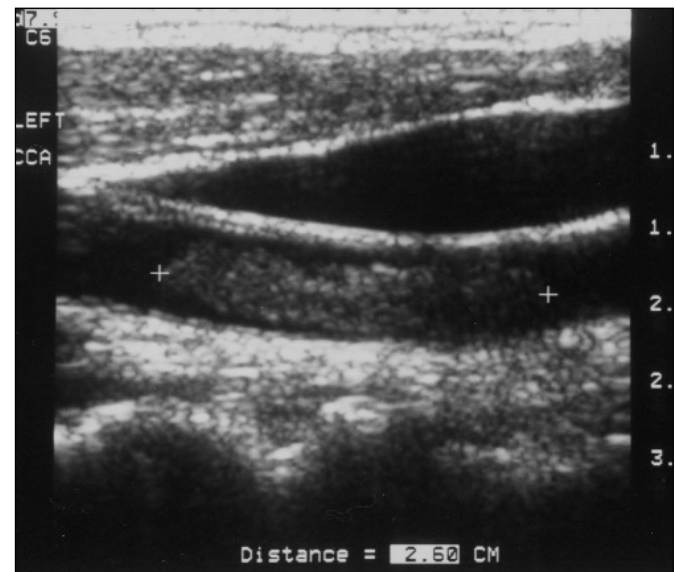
Gray scale, sagittal view carotid ultrasound of the left common carotid artery at presentation showing thrombus and no apparent underlying wall defect. By convention, the patient's head is at left and feet at right.
